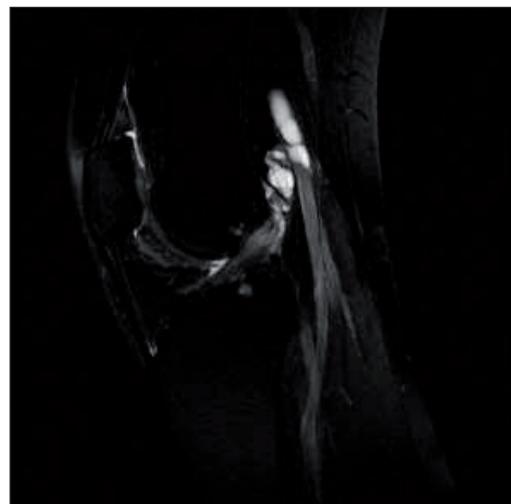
(B) MRI showing genicular branch with cystic degeneration.
